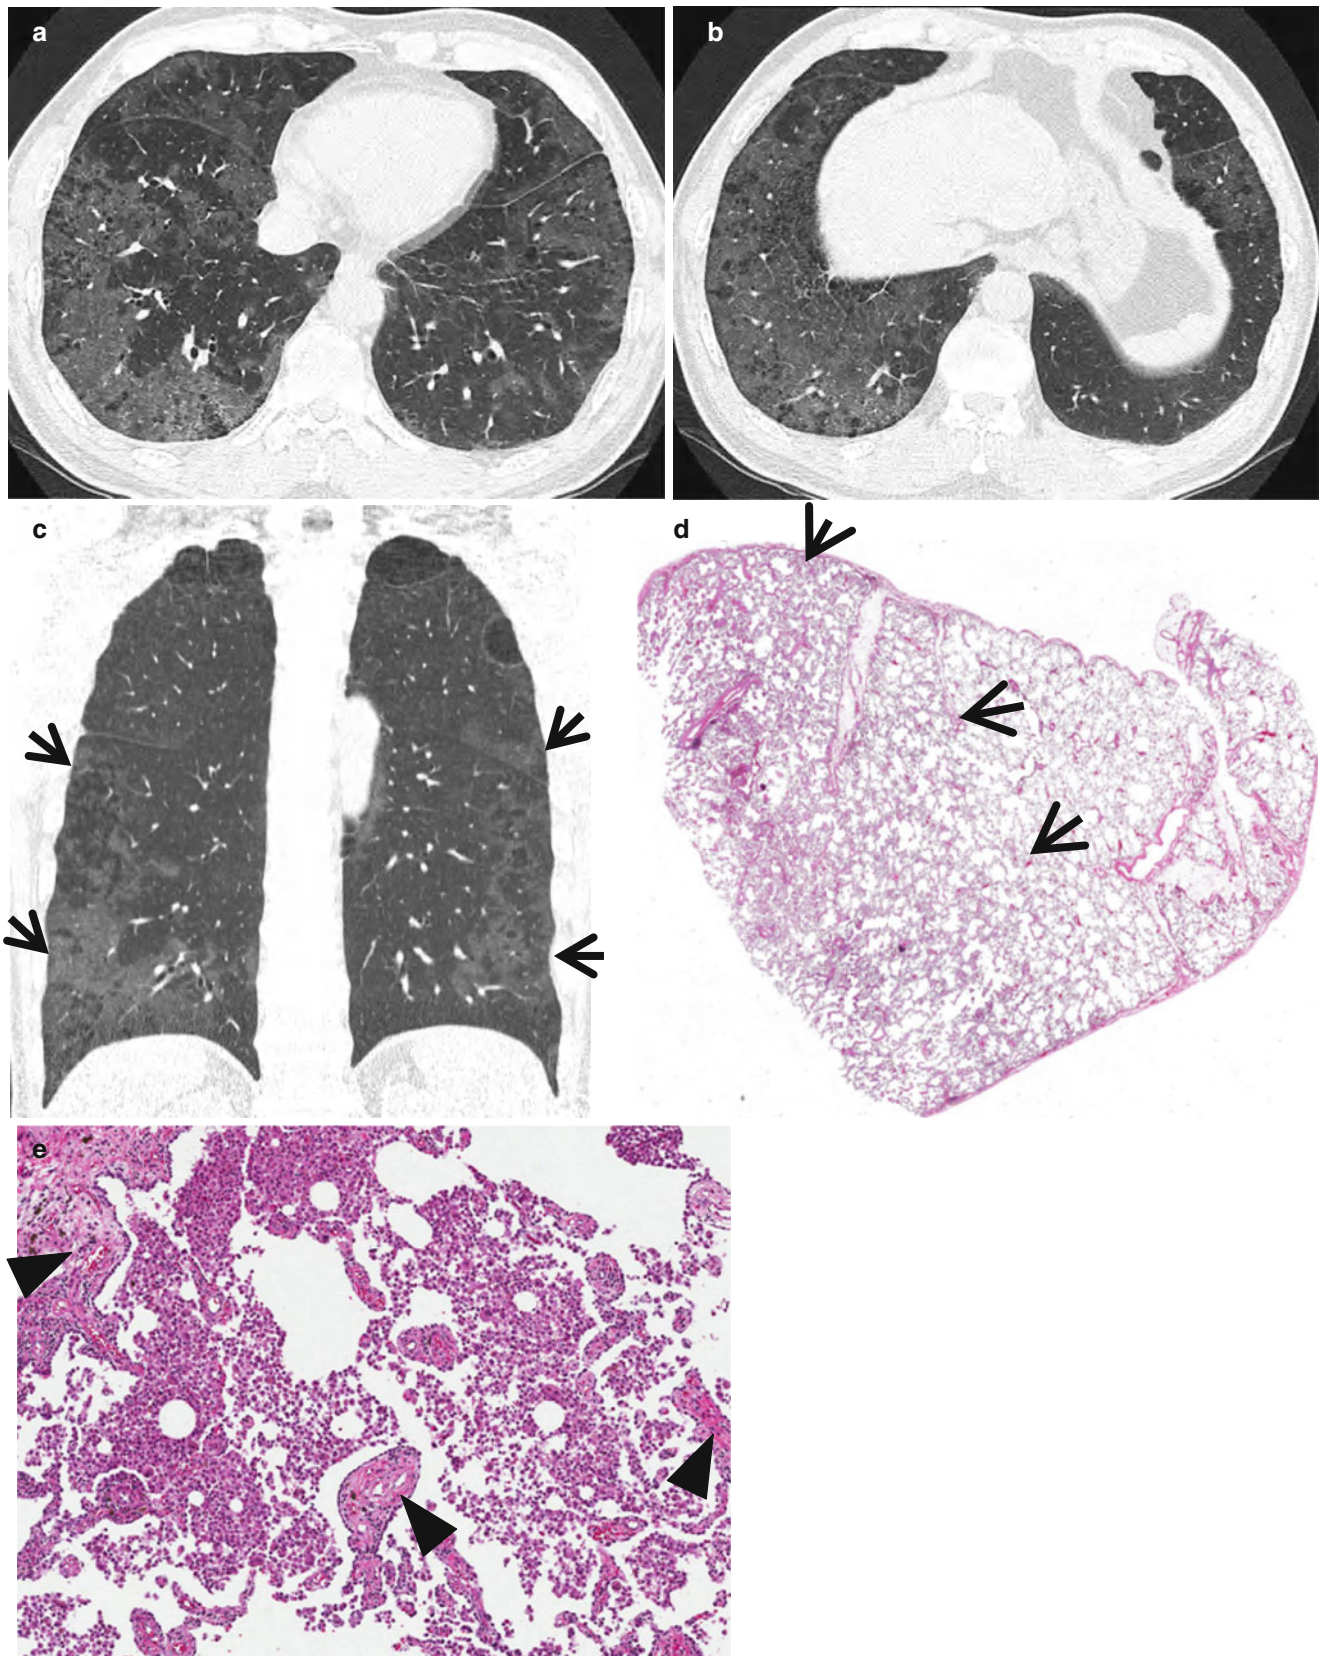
Desquamative interstitial pneumonia presenting as patchy areas of ground-glass opacity without reticulation in a 51-year-old smoker man. (a, b) Lung window images of CT scans (1.5-mm section thickness) obtained at levels of suprahepatic inferior vena cava (a) and liver dome (b), respectively, show patchy and extensive but subpleural areas of ground-glass opacity in both lungs. (c) Coronal reformatted CT image (2.0-mm section thickness) demonstrates subpleural patchy
